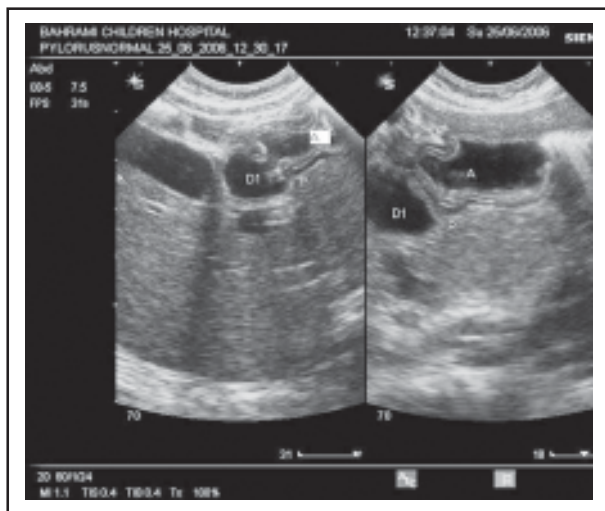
Longitudinal sonogram of normal pylorus (P) in relaxed (left sided image) & closed (right sided image) positions. D1= Duodenal cap, A = Distal antrum.
